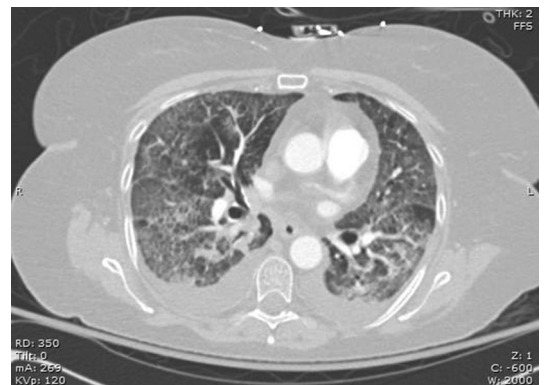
Computed tomography of the chest revealing diffuse ground-glass opacities and small bilateral pleural effusion in a 62-year-old female patient with respiratory syncytial virus infection who developed pneumonia and acute respiratory distress syndrome.
